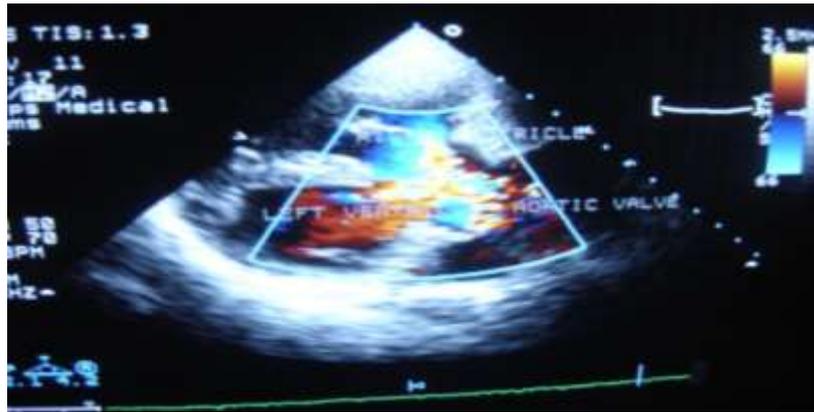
Transthoracic 2D and Doppler echocardiography revealed large VSD,with pulmonary atresia with large Major Aortopulmonary Collateral Arteries (MAPCA) and vegetations seen on aortic valve
